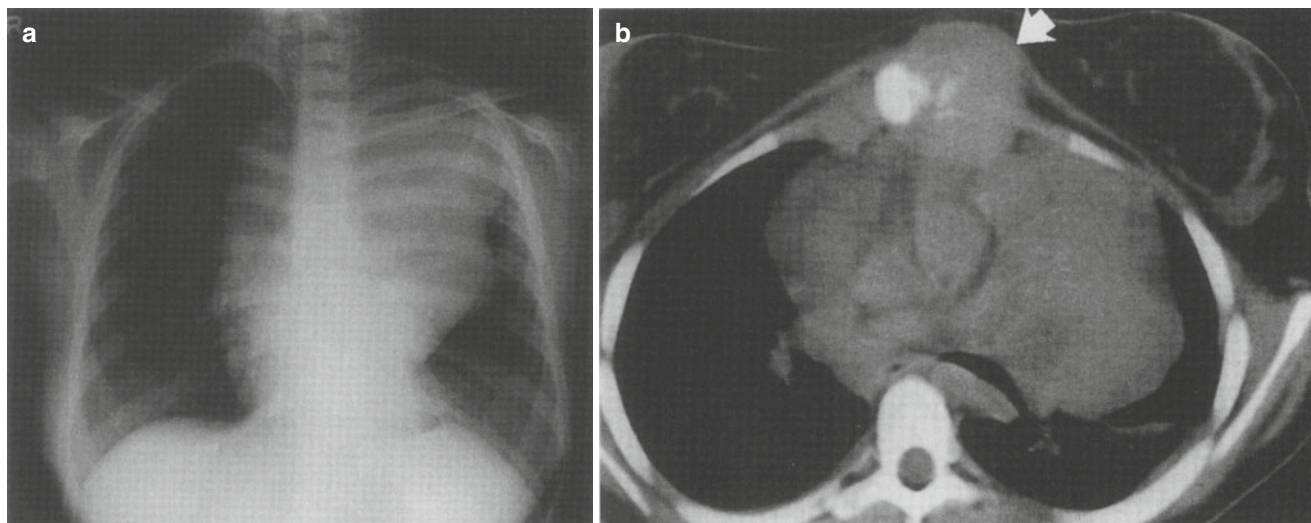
(a) Chest radiograph of a 12 year old girl obtained because of mild left pleuritic chest pain demonstrates a large anterior mediastinal mass. (b) The CT scan revealed that the mass was eroding through the chest wall and sternum (*arrow*). Because of significant tracheal compression a biopsy was obtained under local anesthesia and Hodgkin's disease was diagnosed
